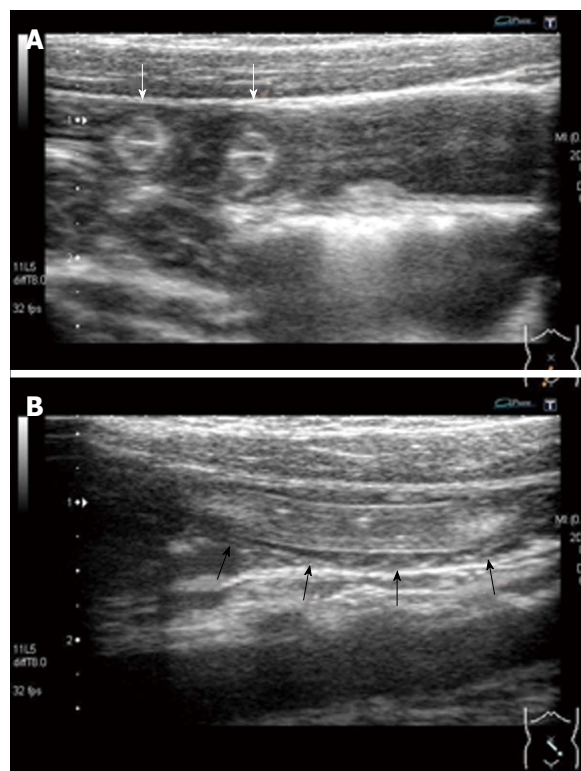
Abdominal ultrasound examination at the pediatric emergency room. A: Ultrasonography shows multiple, round-shaped structures with a target-like appearance within the small intestine (white arrows); B: In a longitudinal scan of the small intestine, ultrasound shows a tubular structure with two parallel, outer high echogenic lines (black arrows). Space between the intestinal wall and the tubular structure was not observed.
